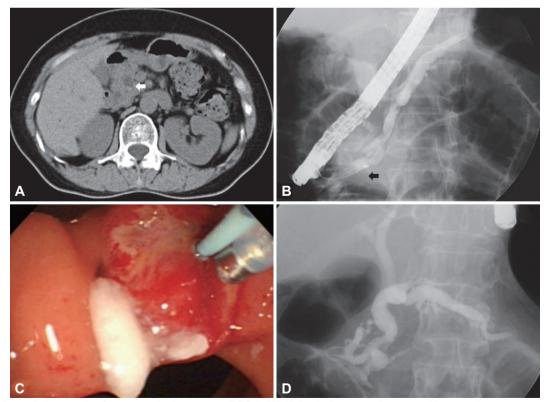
Endoscopic intervention for pancreatic duct stones (PDSs). (A) Abdominal computed tomographic scan shows a 4 mm sized calcified stone (white arrow) in pancreatic head within dilated pancreatic duct. (B) Small size of the PDSs let basket removal possible (black arrow). (C) PDS was visualized intraluminally. (D) No filling defect was observed in the main pancreatic duct after complete stone removal.
